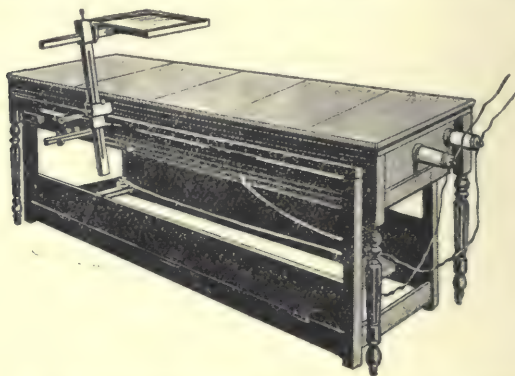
An improvised X-ray table designed by Dauneau.
